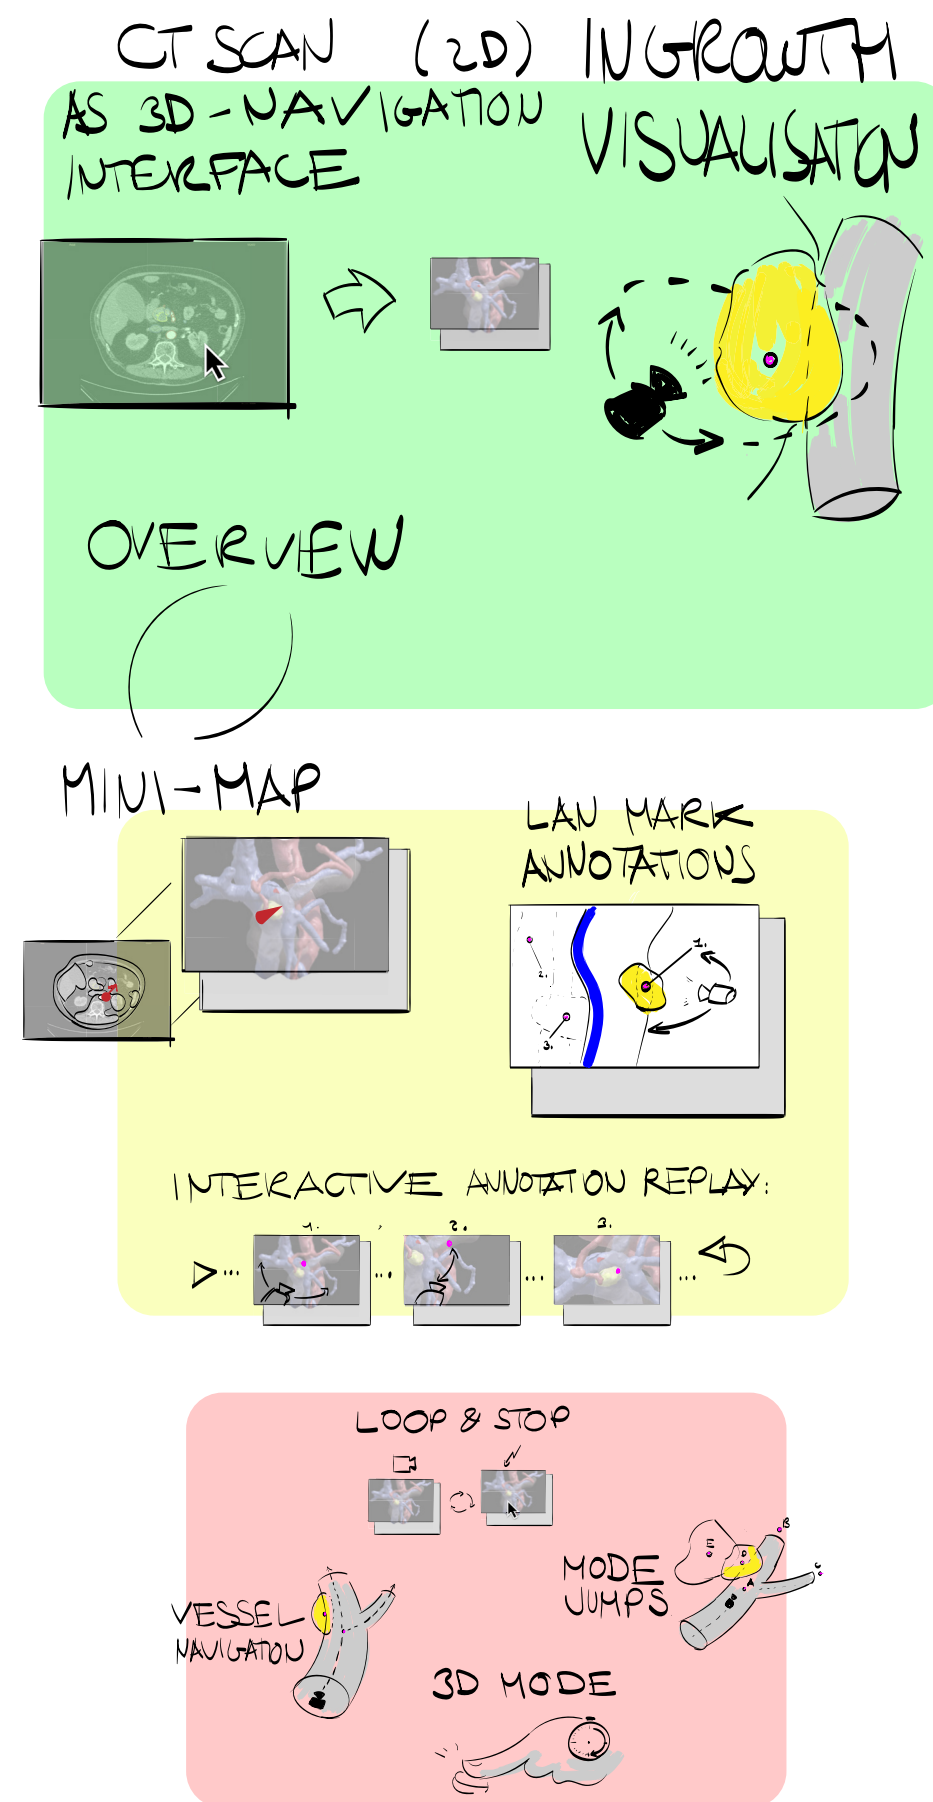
Three tiers of desirability. The concept chosen to combine for the design direction, were the „CT scan as a 3D navigation system,” „Ingrowth visualisation”, and the „overview”
